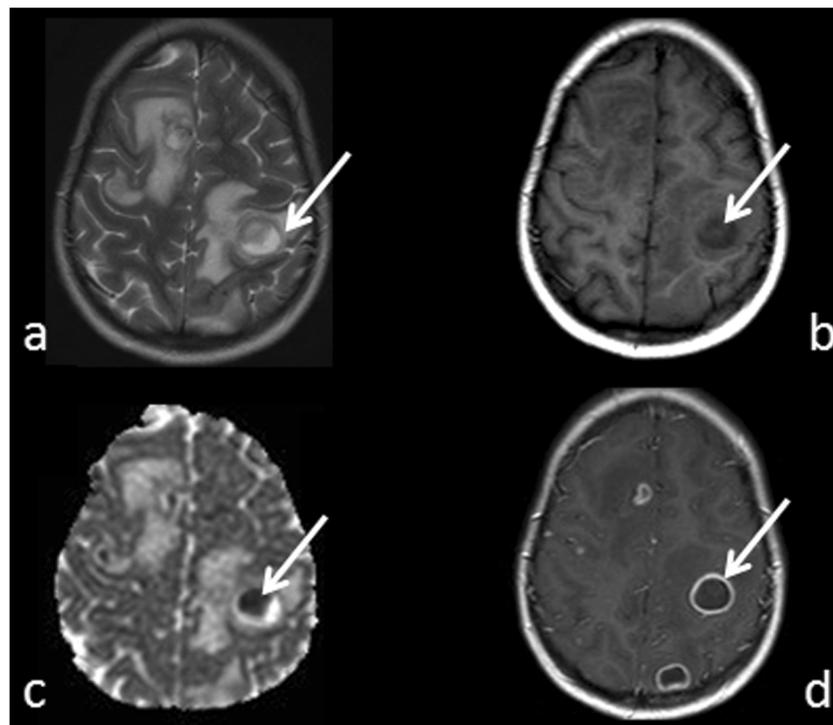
Brain abscesses from *aspergillus fumigatus* infection. MR imaging study in a 13-year-old girl affected by multiple fully developed brain abscesses from *aspergillus fumigatus* infection. The heterogeneous content of the abscesses is the main feature helping in differentiating from bacterial-pyogenic abscesses. a Axial T2 and b T1-weighted sections showing multiple brain focal lesions, the larger one (arrows) characterized by regular iso-hypointense T2-weighted rim and containing amorphous material in an eccentric nodule; c the corresponding apparent diffusion coefficient (ADC) map demonstrating
